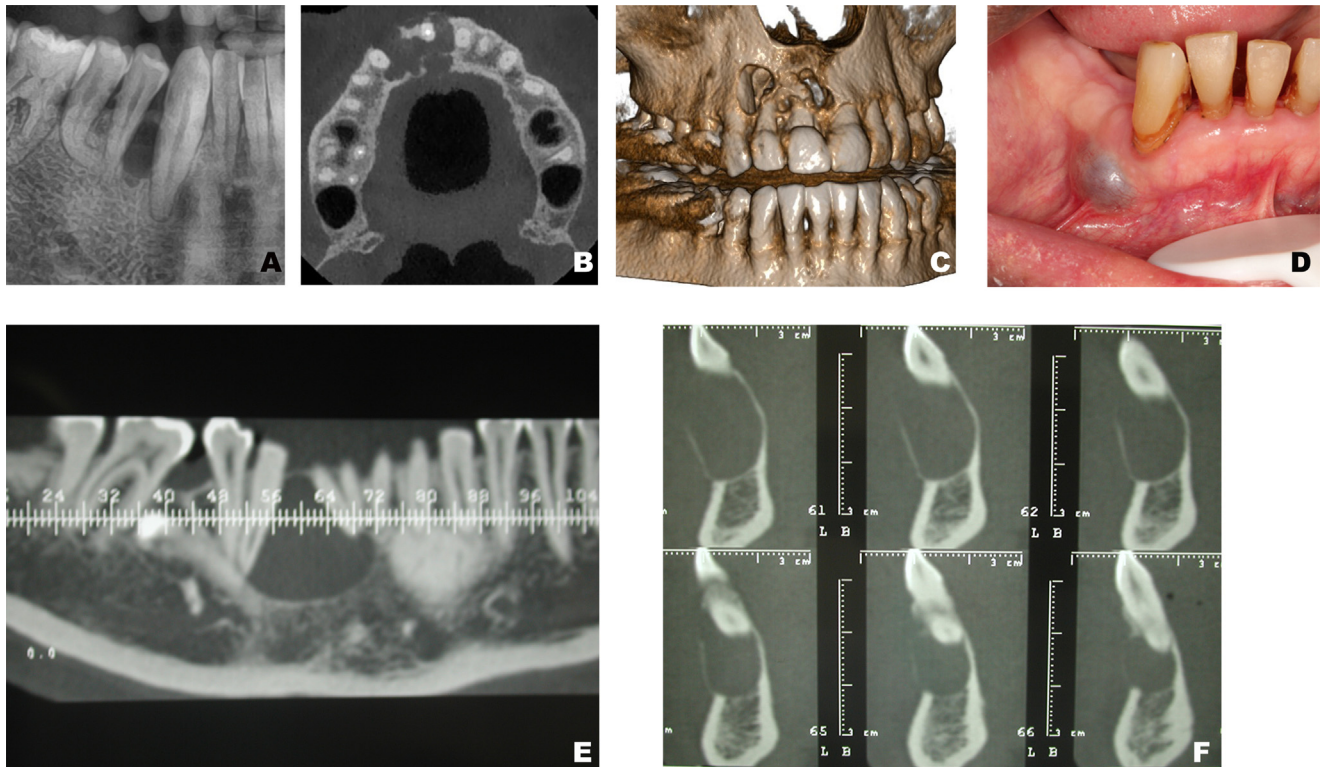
Radiological features of odontogenic cysts lined by an epithelium with plaque-like thickenings. (A) Panoramic view showing an unilocular radiolucency consistent with a LPC. (B/C) CBCT sections showing confluent multilocular radiolucencies consistent with a BOC. (D) Clinical view showing a bluish nodule consistent with a gingival cyst. (E/F) CBCT sections showing a unilocular radiolucency with tooth displacement. The final diagnosis was a GOC.
